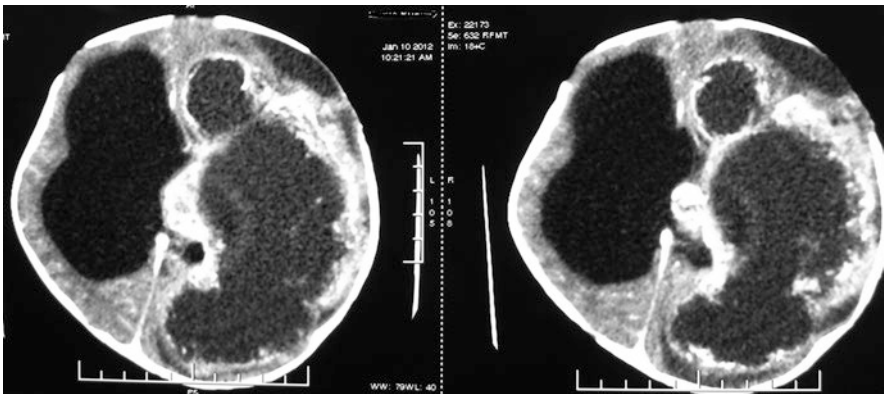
MRI of a 5-month-old female with a massive non-medulloblastoma embryonal tumor of the left lateral ventricle
